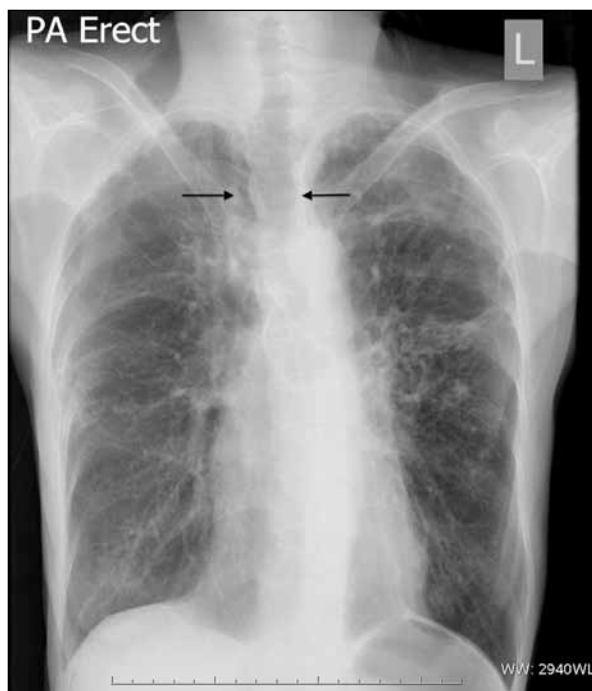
A chest radiograph shows a prominent trachea, with an irregular outline (arrows). Bilaterally, the lung field yields increased reticulonodular changes, suspicious of infective changes
